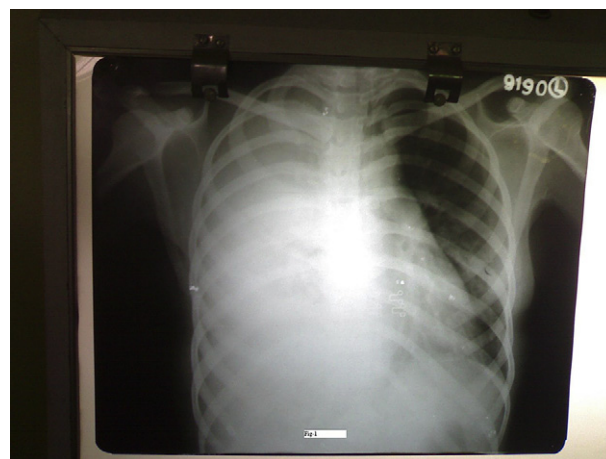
Chest X-ray PA view shows homogenous opacity with blunting of right CPA without air-bronchogram.
